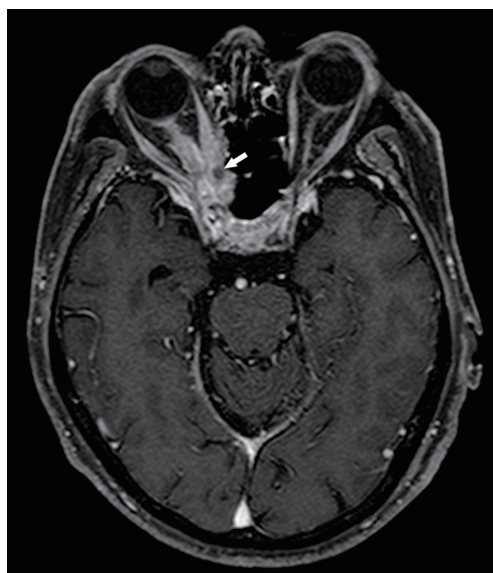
The brain MRI with contrast disclosed extensive contrast enhancement along the right optic nerve, optic canal, and cavernous sinus with a rim-enhancing lesion (arrow) in the posterior aspect of the optic nerve.
